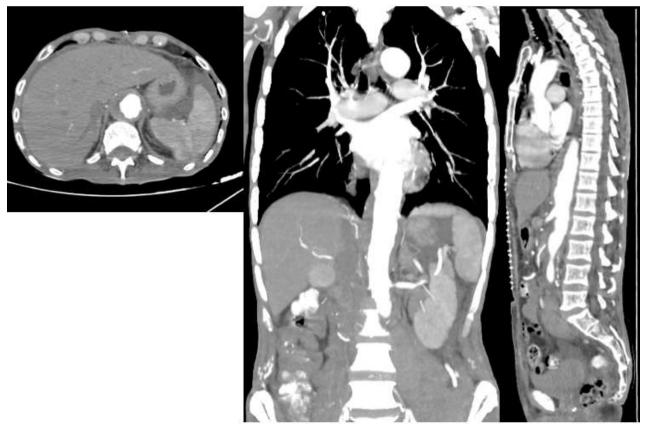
Abdominopelvic CTA showing an abdominal aortic aneurysm measuring 46mm in diameter and extending over 107mm, with partial thrombosis above the renal arteries, and complete thrombosis at the infrarenal level, extending bilaterally to the iliac arteries.
